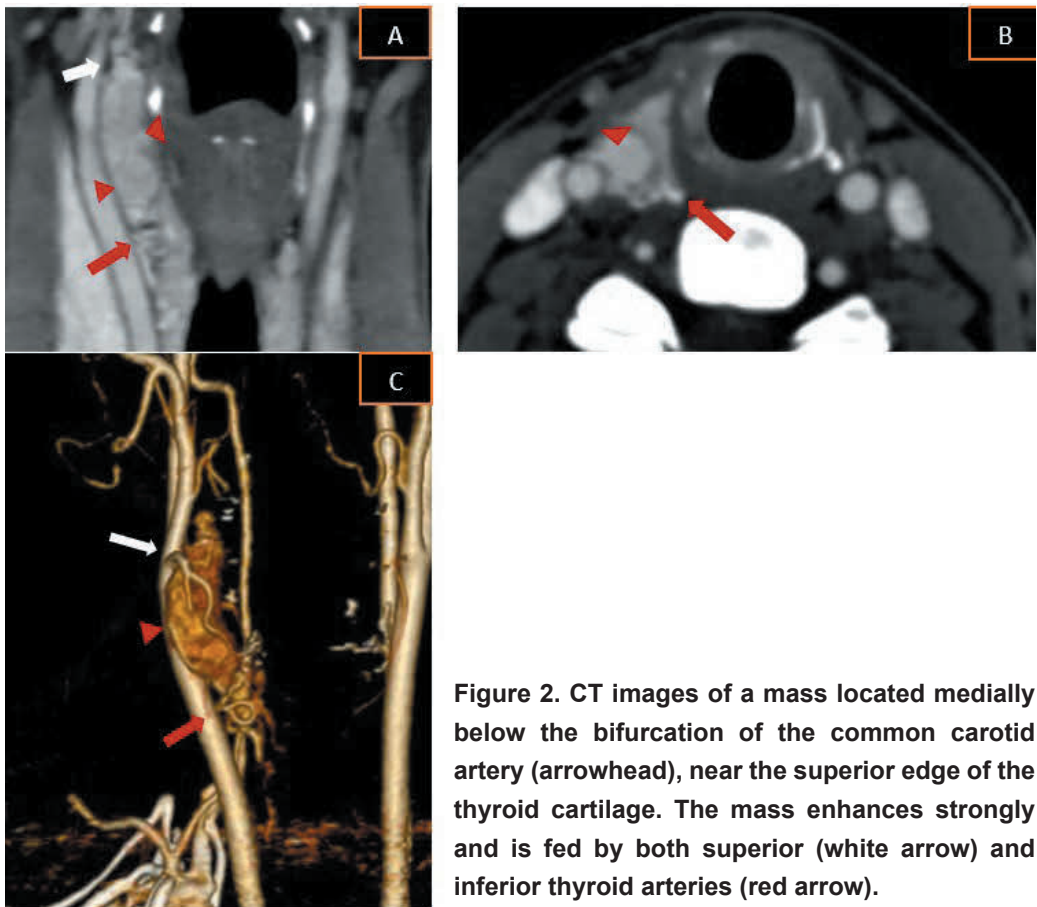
CT images of a mass located medially below the bifurcation of the common carotid artery (arrowhead), near the superior edge of the thyroid cartilage. The mass enhances strongly and is fed by both superior (white arrow) and inferior thyroid arteries (red arrow).
